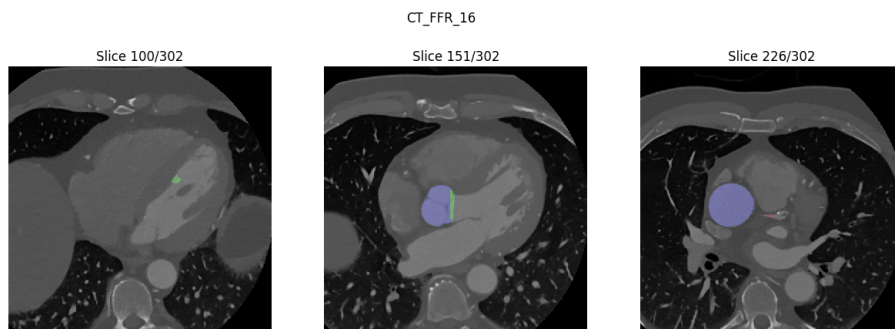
A selection of some of the CT slices of the BVNet model's worst prediction of the Aorta split-2, where the corresponding prediction is overlaid. The prediction is color-coded with blue=TP, green=FP, and red with low opacity=FN
